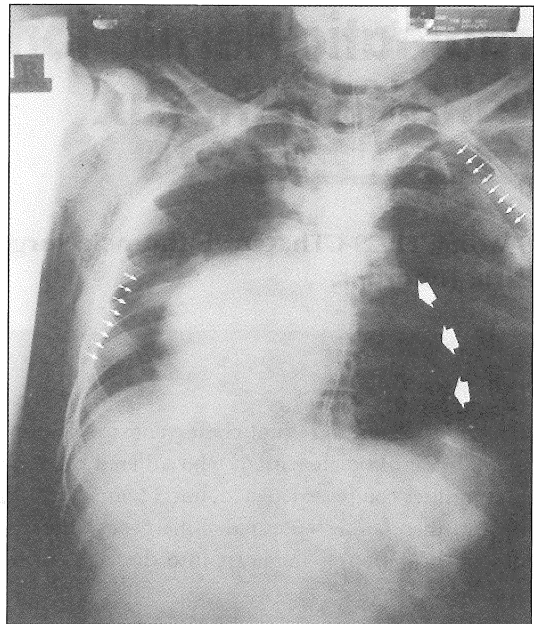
Chest radiograph of the patient on admission to hospital.
